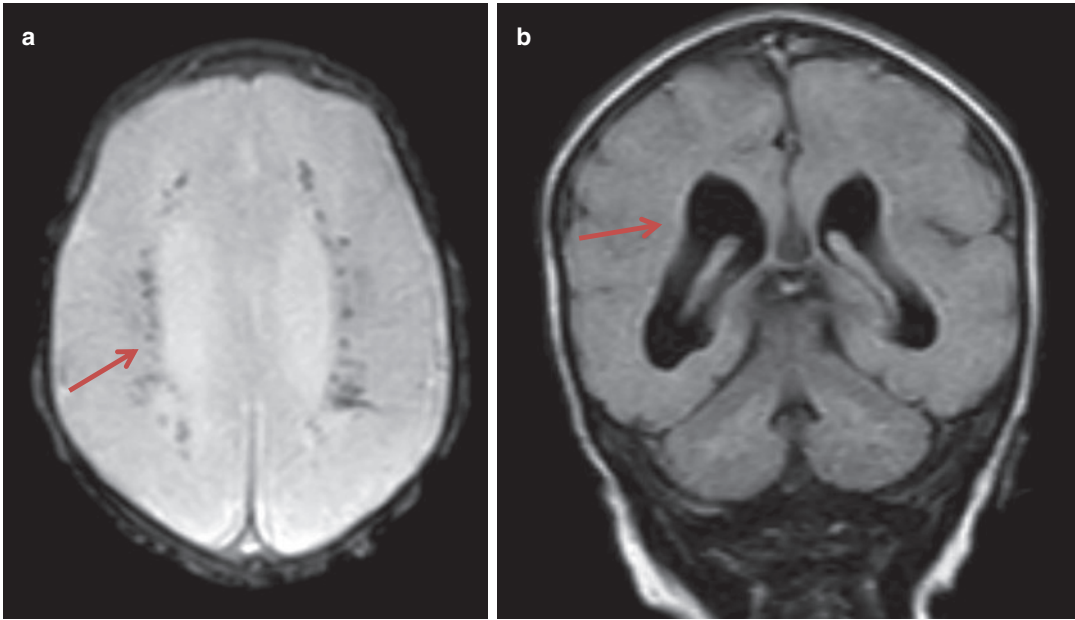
Magnetic resonance imaging of brain from a patient with Aicardi Goutières syndrome (homozygous *TREX1* mutation). (a) Shows widespread intracerebral
